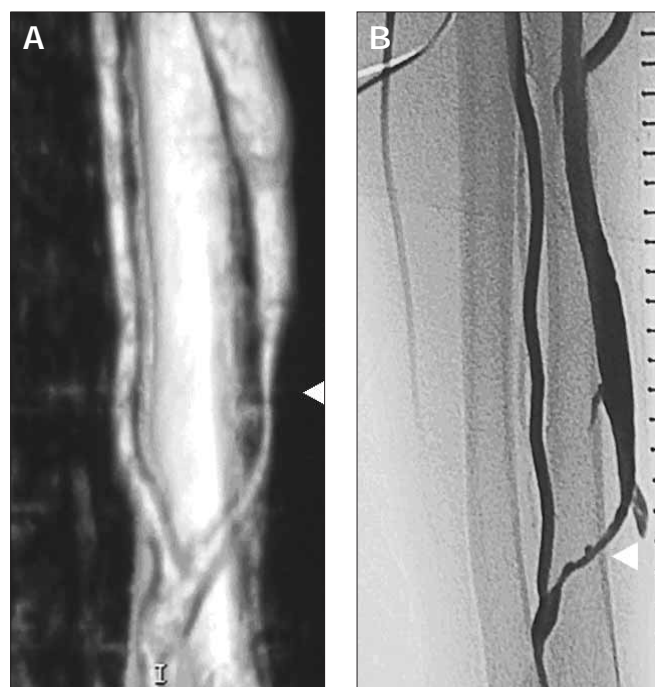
Semicoronal image obtained with MS-CTA of a radial-cephalic AVF, displayed a grade 4 stenosis in the efferent vein (arrow head).
